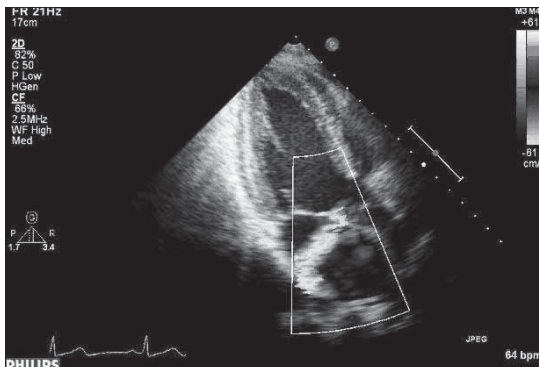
Transthoracic echocardiographic view of the perforation
